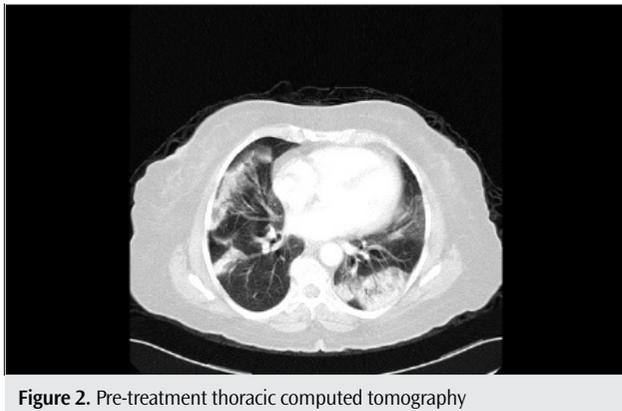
Pre-treatment thoracic computed tomography
